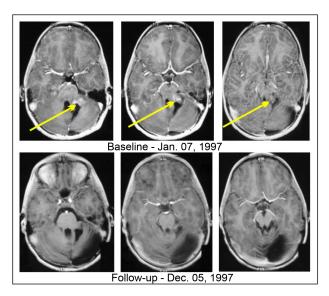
Pilocytic astrocytoma of the cerebellum in a 6-year-old male treated in the study from January 14, 1997 to October 15, 1998. Recurrence after gross total resection of the tumor on August 12, 1996 without radiation therapy or chemotherapy. MRI of the head, T1 post-contrast. Baseline versus follow-up showing complete response. Overall survival from treatment start is over 19 years. The yellow arrows indicate contrast-enhancing lesions.
